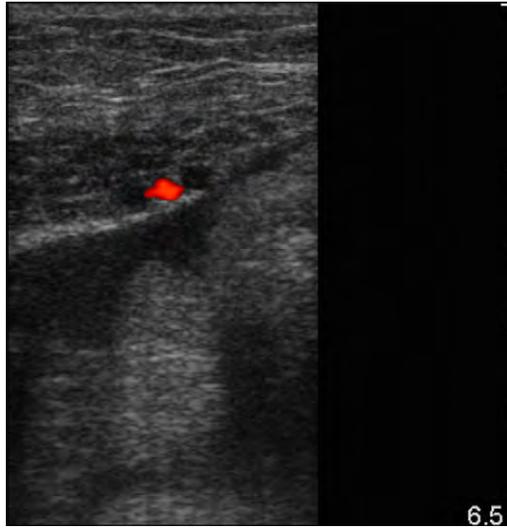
Doppler image demonstrating inferior epigastric artery.
